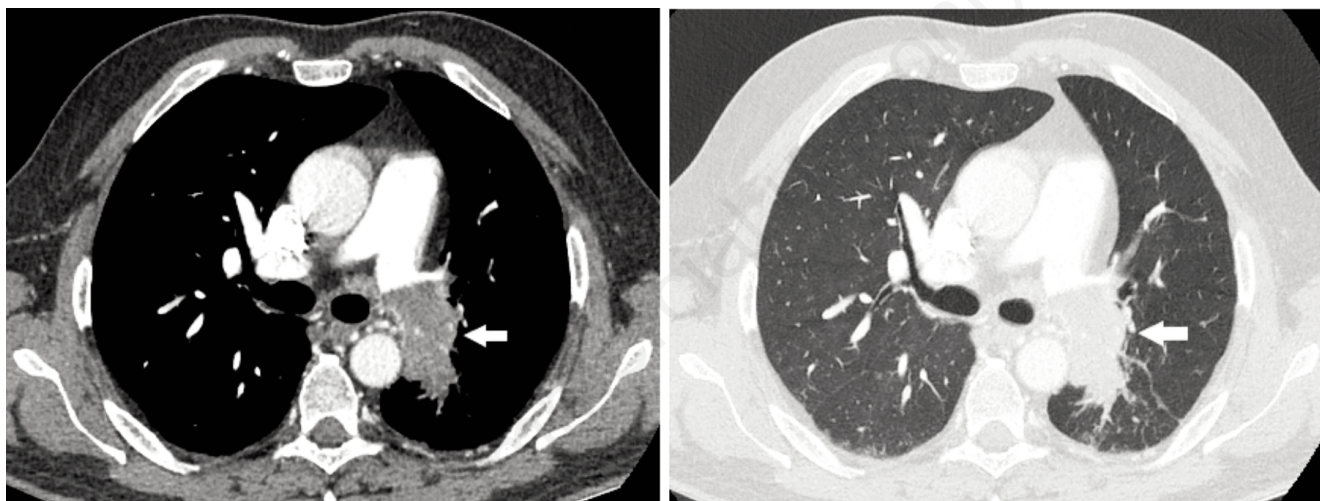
Computed Tomography (CT) axial images before surgery showed a central lung inflammatory myofibroblastic tumor, occluding the left main pulmonary artery.
